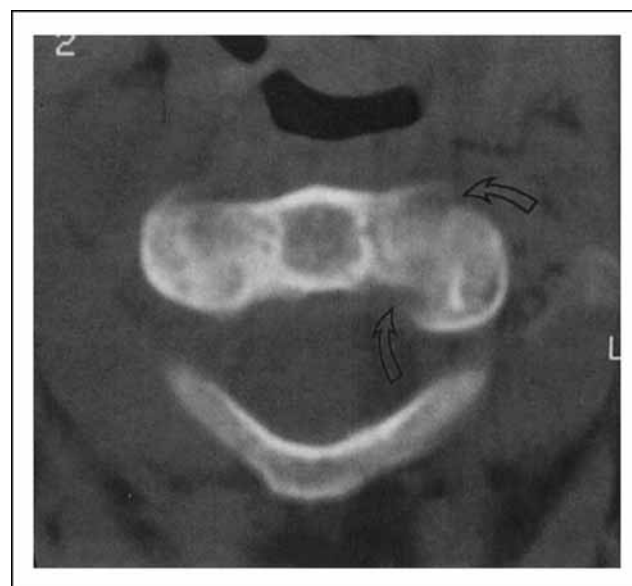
CT of the spine of patient 3 showing linear fracture of C-2 (arrows).
